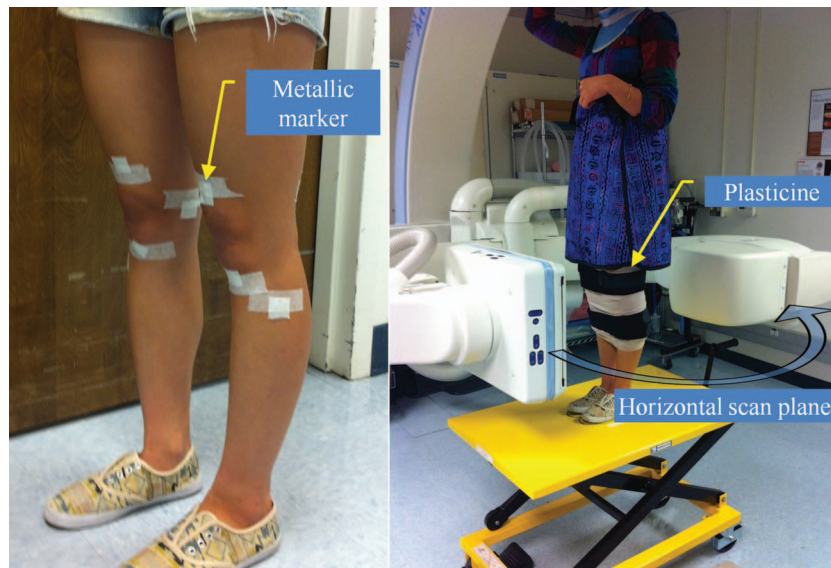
Each volunteer was scanned while standing in a C-Arm CT. The C-Arm rotates in a horizontal plane. Nine tantalum metallic markers were suitably attached around the knee. Both legs were wrapped with modeling clay to prevent saturation artifacts.
